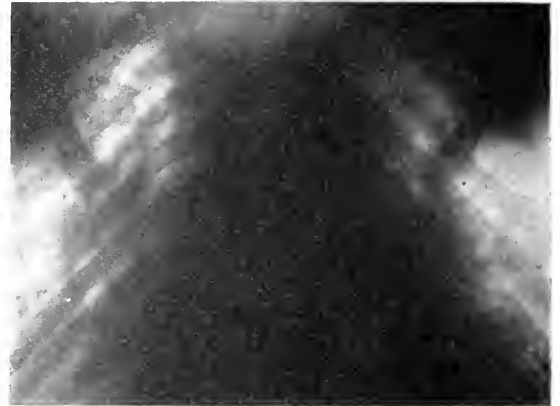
And. D. Roentgenogram taken May 14, 1916.
